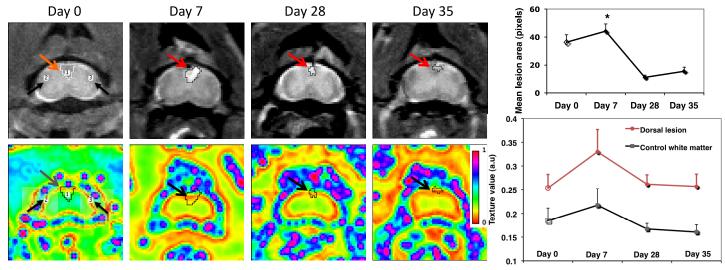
Sample T2 MR images and corresponding texture maps of dorsal lesions (arrows) over time (left panel). Highlights at day 0 reflect normal area (top) or texture (bottom) of dorsal column, and control white matter (black arrows) of the spinal cord. Quantitatively, lesion size (top right panel) decreased more prominently with remyelination than texture heterogeneity (bottom right) which remained coarser than intact myelin (day 0). It also appears that dorsal column was initially coarser than lateral spinal white mater, which is subject to confirmation. Bars are standard error.
